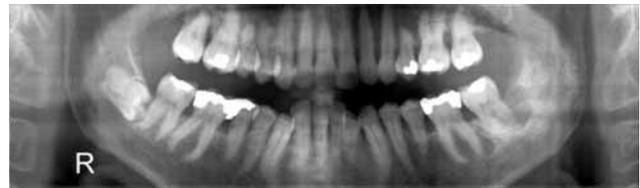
Panoramic radiograph of the same case to give us all the information we need for the surgical removal of the root residues
